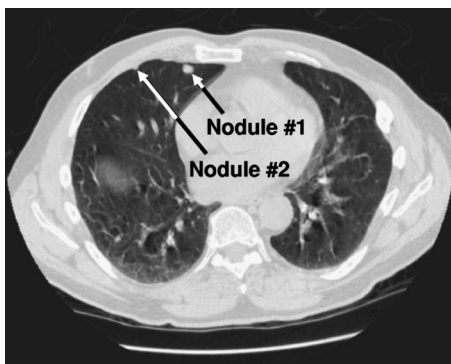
A CT slice containing significant dependent atelectasis in our secondary data set. A subtle juxta-pleural nodule (nodule 2) that was detected by the CAD program is at the upper chest wall, in addition to the 8.5 mm lobulated nodule (nodule 1) located medial to it.
